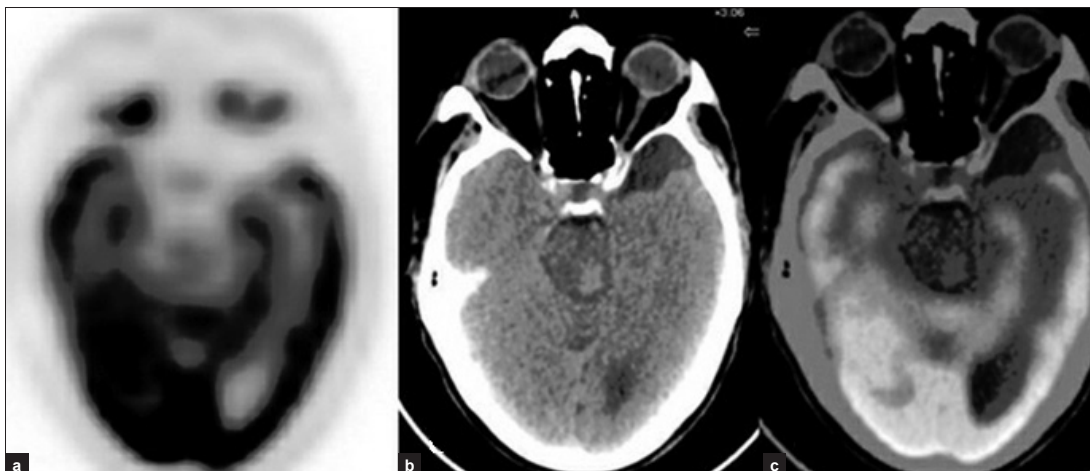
(a, b, c) Axial plain PET, CT and fused PET/CT of a 70-year male Ca lung undergoing evaluation for bone mets shows hypo-dense well margined extra-axial lesion suggestive of small arachnoid cyst in the left temporal pole on CT with the adjacent part of cortex showing normal FDG distribution
